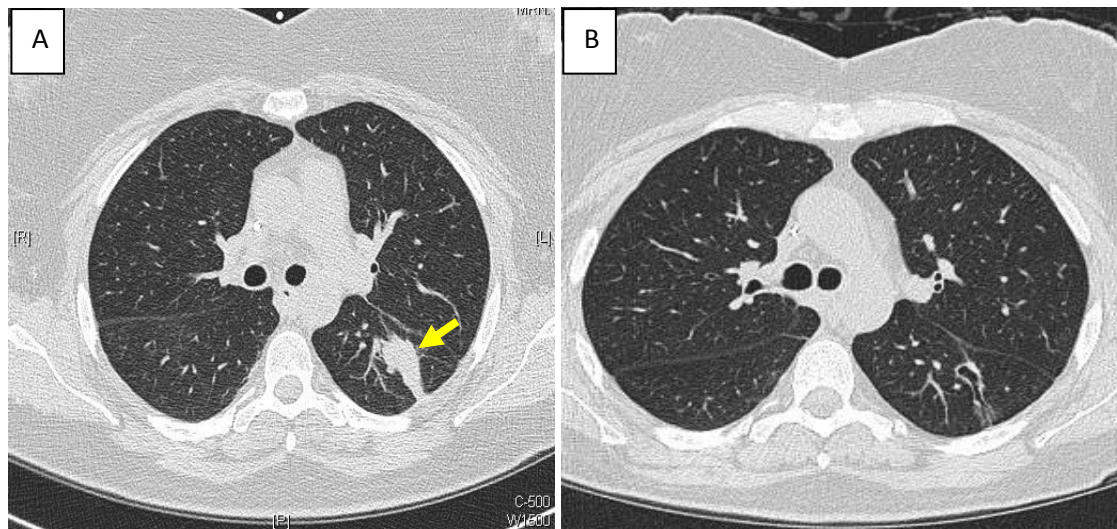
Baseline CT scan of the chest (A) showing a nodule in the left lower lobe (arrow). A repeat scan 7 months later showed resolution of the nodule (B) without antifungal therapy
